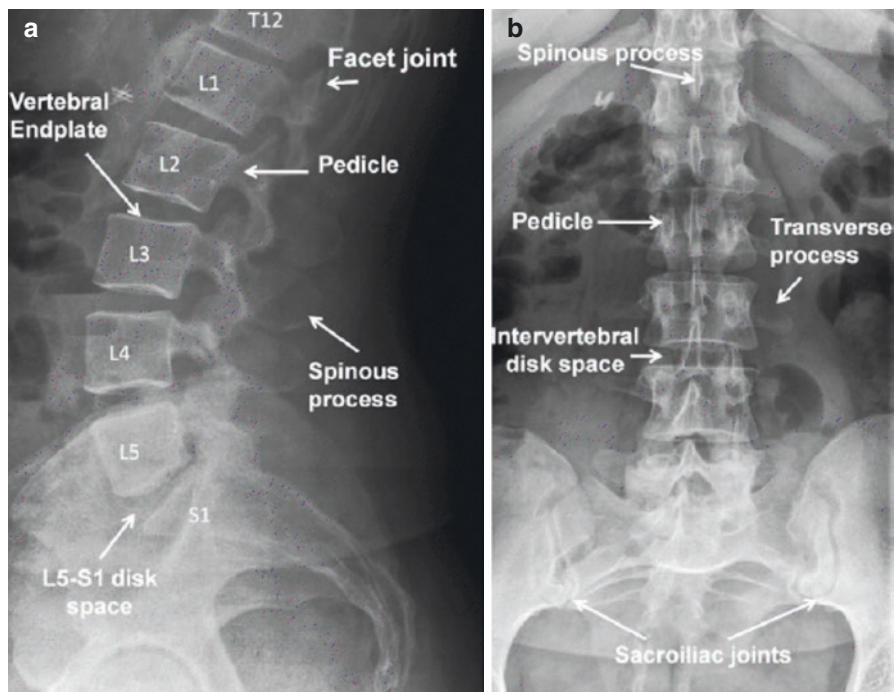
Lateral and AP radiograph of the lumbar spine with relevant anatomy labeled. (From: Valladares-Otero [33]. Reprinted with permission from Springer Nature) (a) X-Ray Lateral View Lumbar Spine. (b) X-Ray Anterior-Posterior View Lumbar Spine
